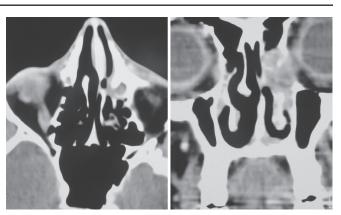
Axial and coronal sections of contrast-enhanced CT scan of nose and paranasal sinuses show a well-circumscribed lesion in left lacrimal sac with widening of the nasolacrimal duct
